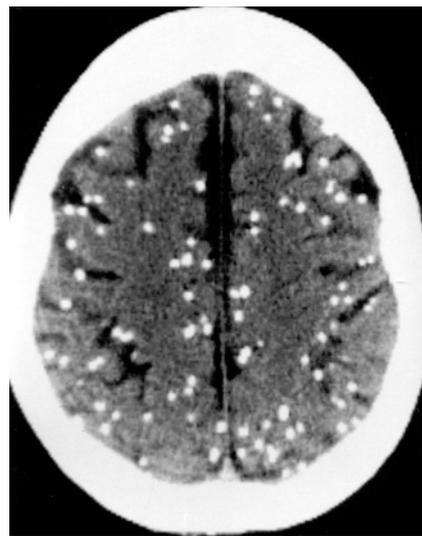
Unenhanced CT scan demonstrating calcifications as a result of cysticercus degeneration
